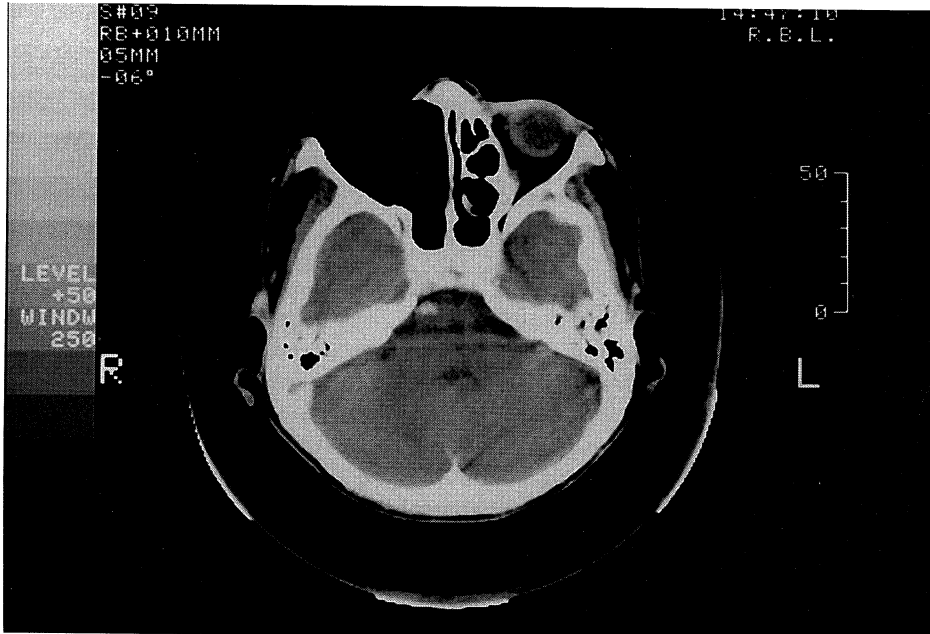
CT scan after operation showed no tumor in the right maxillary region
